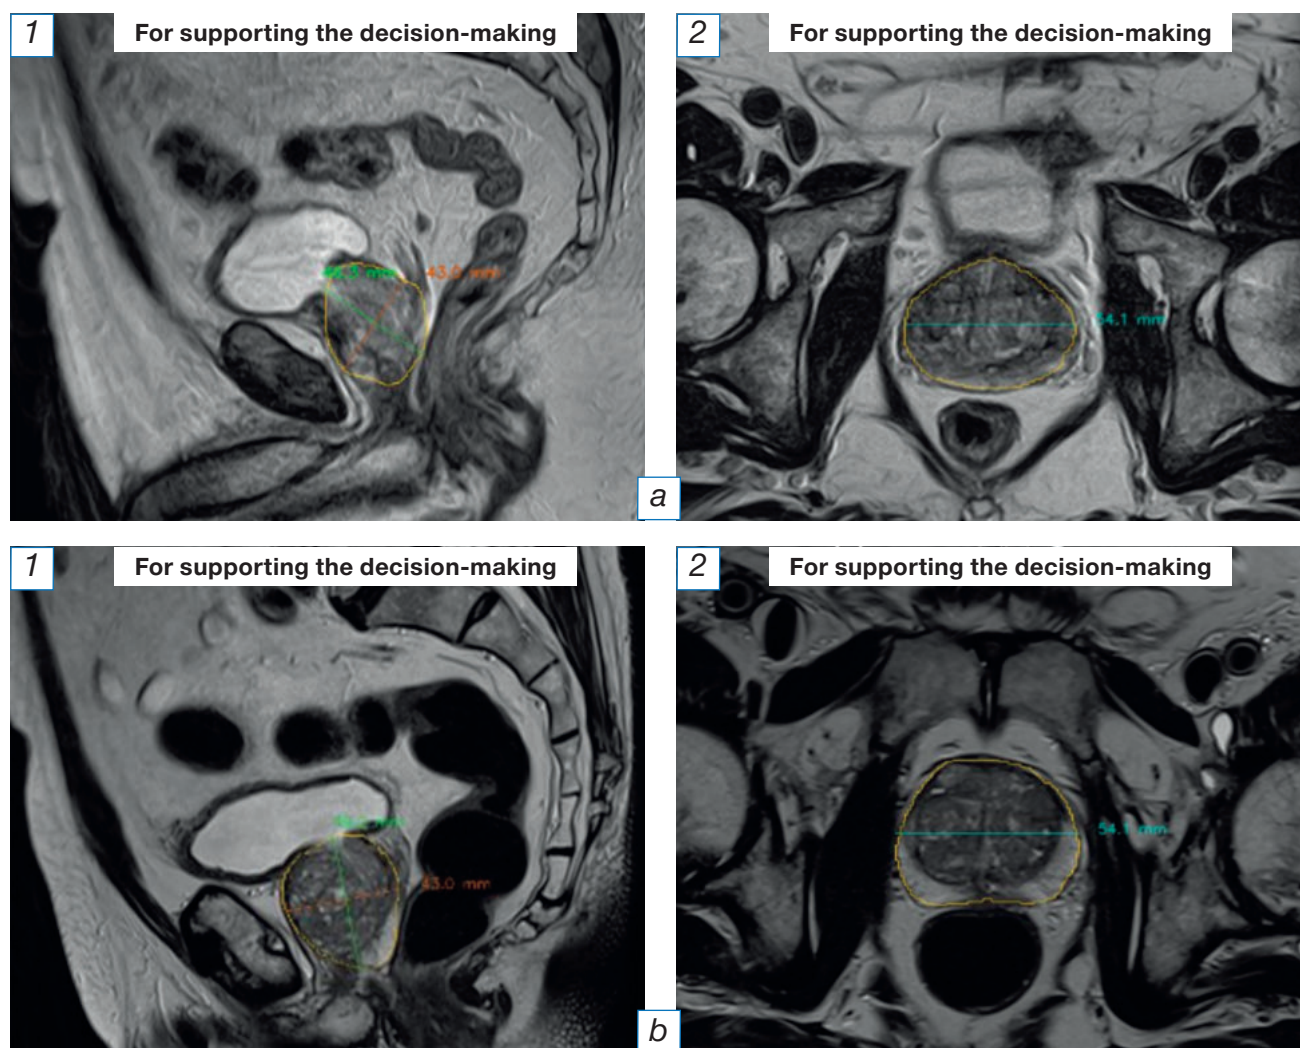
The results of magnetic resonance imaging of the lesser pelvis organs in males aged 65 (a) and 67 (b) years, analyzed by the AI-service: segmentation and morphometry of the prostate gland were done correctly. 1 — sagittal projection; 2 — axial projection.
